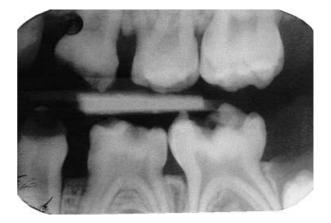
Left-hand-side bitewing radiograph.
